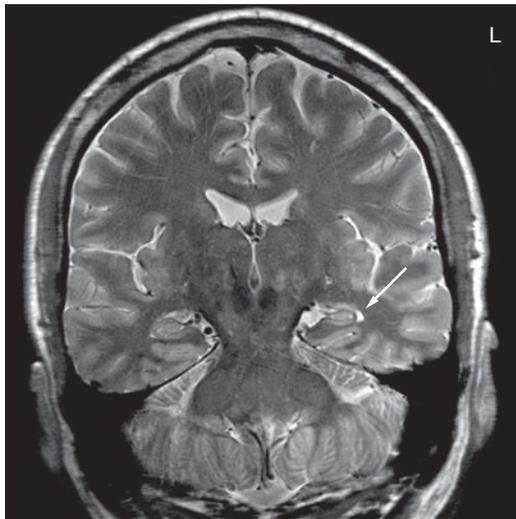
4-Tesla fast spin-echo MRI sequence from a patient with transient epileptic amnesia. The sequence was acquired at the time of detailed neuropsychological testing. The image shows focal atrophy of the left hippocampus (arrow). Abbreviation: L, left.
